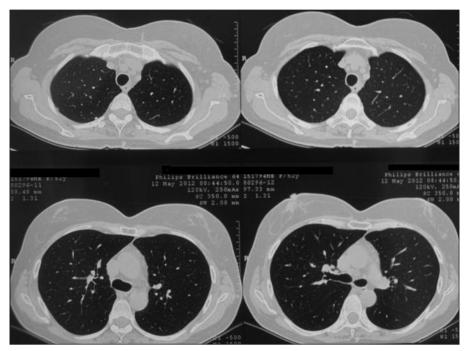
Computed tomography at the end of the 1st year of the prednisolone therapy manifests regression.
